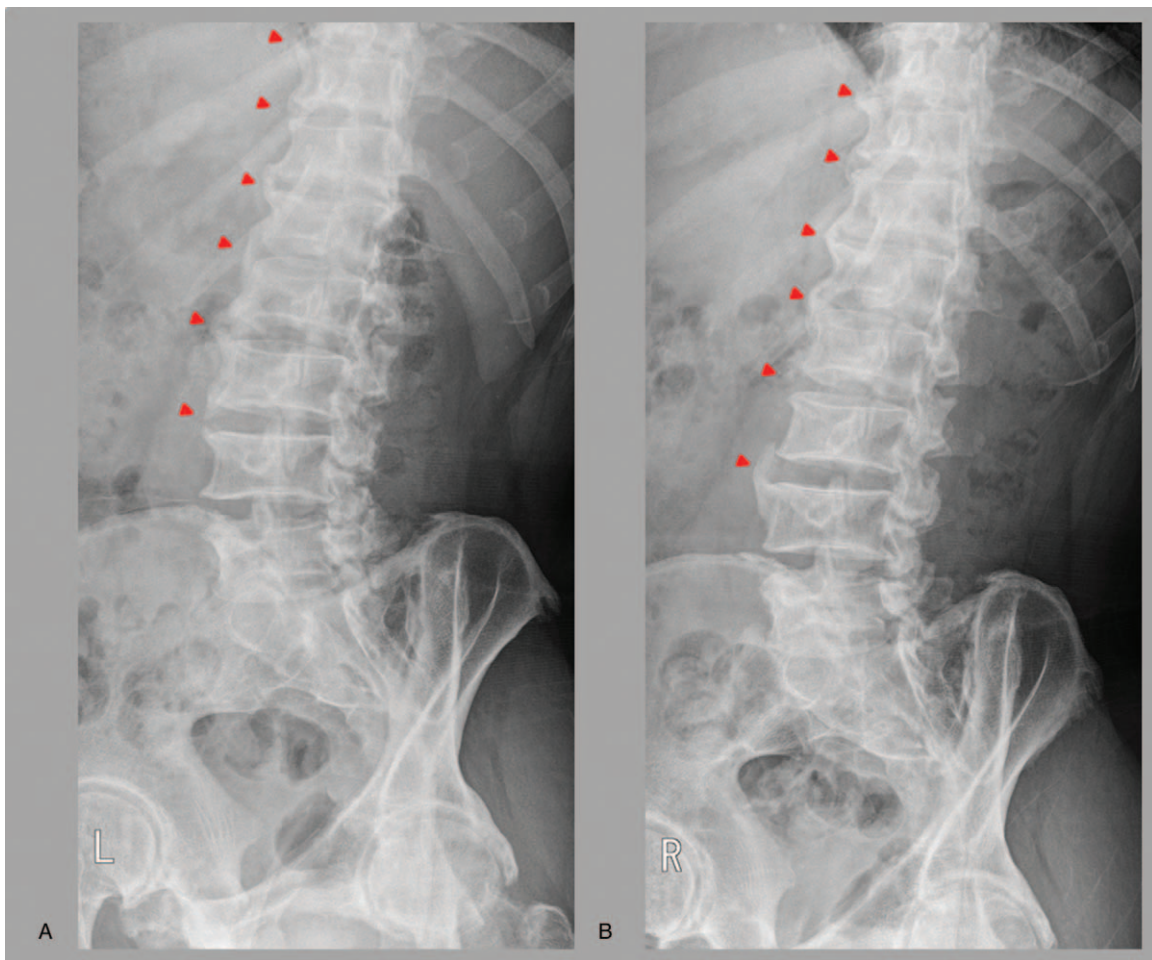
Left (A) and right (B) oblique thoracolumbar spine X-rays show bridging ossification of both right- and left-side anterolateral aspects of 7 contiguous vertebrae (T10 to L4) (red arrow heads).
